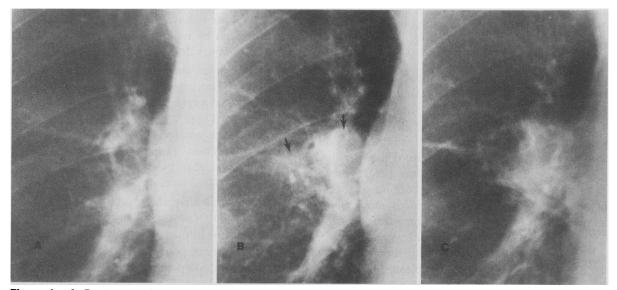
A, Posteroanterior roentgenogram of right hilar area. B, Growing mass 14 months later lateral to and in superior pole of hilum (arrows) was missed. C, Larger mass five months later proved to be adenocarcinoma by bronchoscopic biopsy.
